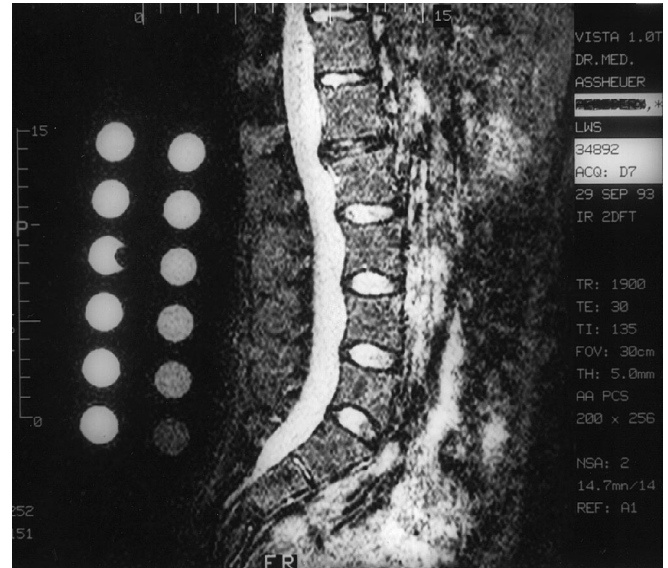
T2-weighted magnetic resonance (MR) image of the lumbar spine. The two calibration devices on the left contain K_2HPO_4 in six concentrations and H_2O/D_2O in five concentrations
